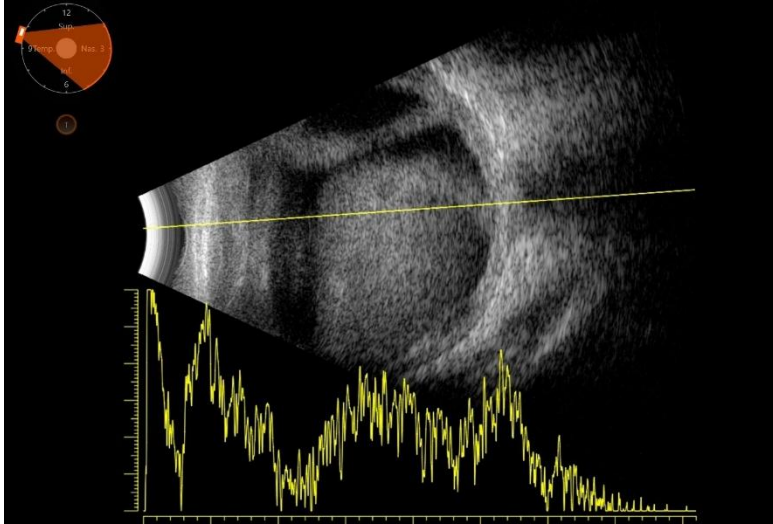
B mode ultrasound showing suprachoroidal hemorrhage with “kissing choroids” at postoperative 20th day
